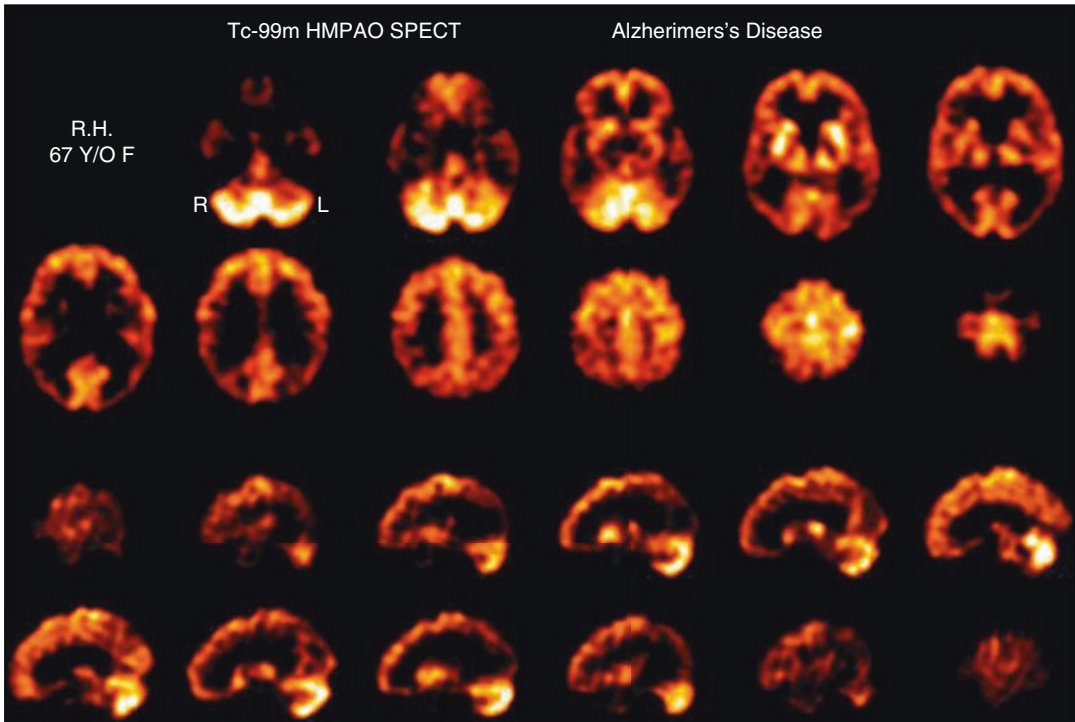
Transverse sections (*top*) and sagittal sections (*bottom*) from a ^{99m}Tc -HMPAO brain SPECT scan of a 67-year-old female with Alzheimer's disease. The scans show global decrease in blood flow to essentially all cortical structures (relative to the cerebellum) with accentuation of the decrease in the posterior temporoparietal region. There is relatively spared uptake in the cerebellum, caudate head, lentiform, and thalamus. Alzheimer's
